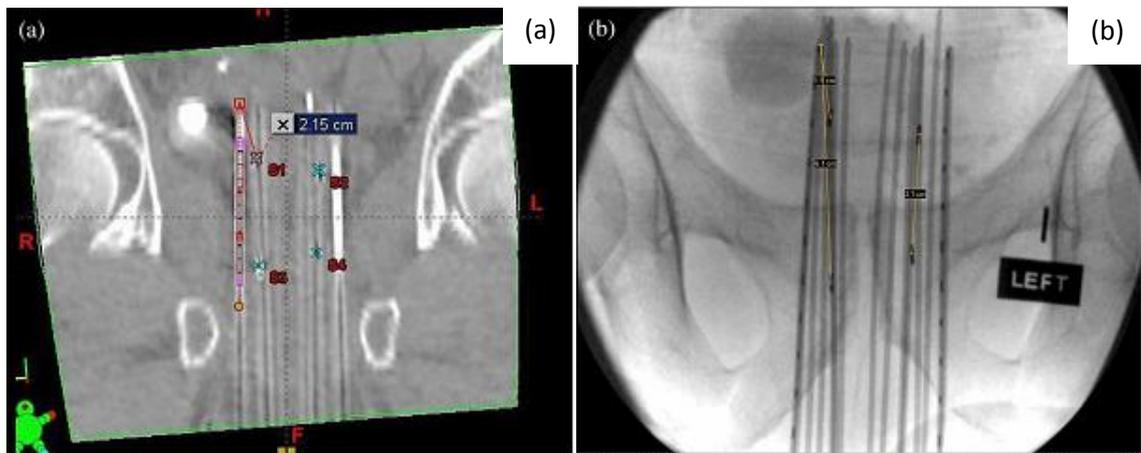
(a) Baseline distance between needle tips and implanted markers on reconstructed CT images oriented to match needles in patient and (b) on AP radiographs before treatment.
